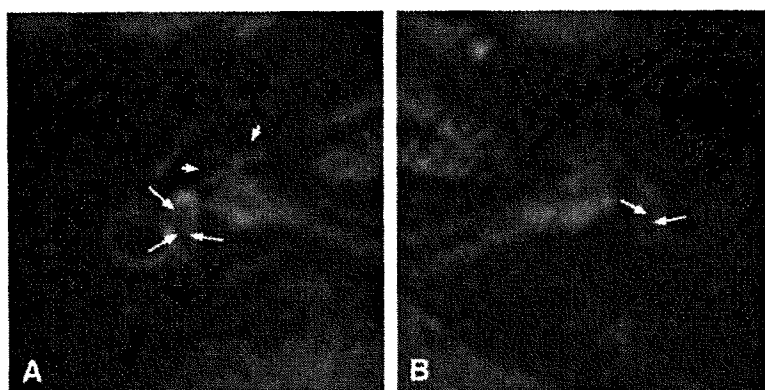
3D-FLAIR MRI of case 2. A, right ear; B, left ear. In A, short arrows indicate endolymphatic hydrops in the basal turn of the cochlea (wedge-like areas). In 3D-FLAIR MRI, endolymphatic hydrops cannot be discriminated from the surrounding bone. In B, no cochlear hydrops is observed. In A and B, long arrows indicate endolymphatic space in the vestibule. The endolymphatic space is clearly larger in A than in B.
